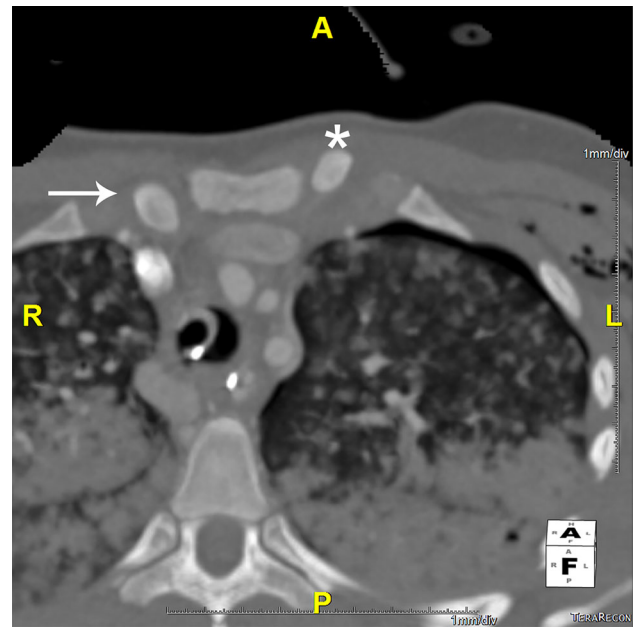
Directed inspection of the sternoclavicular joint is important to avoid missing a sternoclavicular dislocation. Subtle signs of sternoclavicular joint injury include adjacent excess fluid, hematoma, or air. Dislocation or subluxation of the clavicle with respect to the manubrium confirms the injury. Sometimes an indentation of the skin superficial to the clavicular heads heralds the injury. The asterisk marks the anteriorly dislocated left clavicular head. The skin bulge is seen as well and these findings were confirmed on clinical exam. The easiest way to make the diagnosis on CT is to note the asymmetry between the left (asterisk) and right (arrow) clavicular heads and note their vastly different positioning with respect to the joint. Sagittal and 3D images may be helpful as well. Also present are airspace opacities worse in the posterior portions of the upper lobes due to extensive pulmonary contusions and a left anterolateral pneumothorax is seen in the pleural space along with adjacent subcutaneous emphysema
